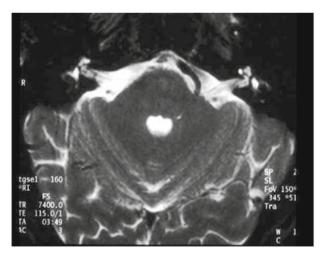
MRI (axial section) showing on left side neurovascular compression at facial root exit zone from brainstem, by vertebral artery and PICA junction, in a patient with left-sided hemifacial spasm
